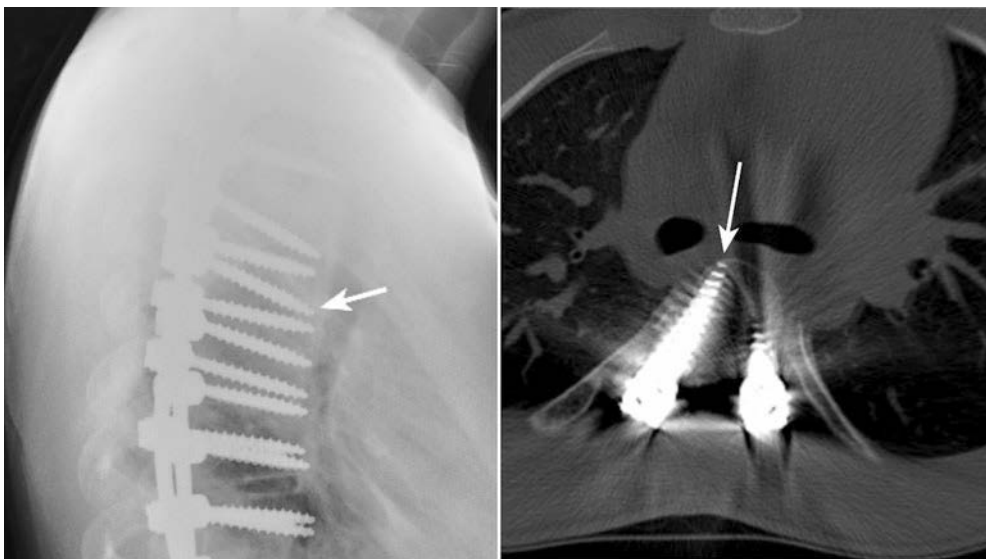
Radiographic film (left) showing an anterior misplacement denoted by the arrow, with the computed tomographic scan (right) showing a normal screw placement, denoted by the arrow.
